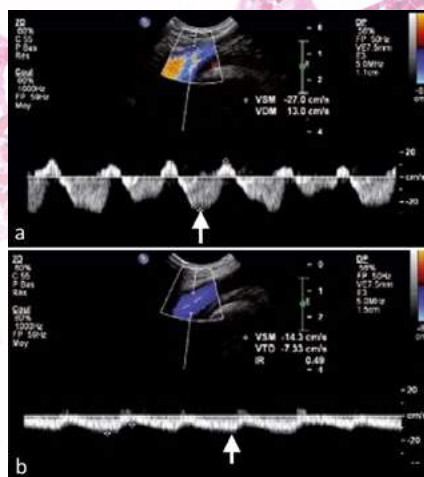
a. Longitudinal triplex doppler scan of the left common femoral vein shows normal phasic flow that fluctuates with respiration. b. On the longitudinal triplex doppler scan of the right common femoral vein, marked dampening of the flow phasicity is noted due to common iliac vein thrombosis. A triplex doppler scan is a scanning mode that delivers a greyscale image with colour and spectral doppler images simultaneously in real-time.
